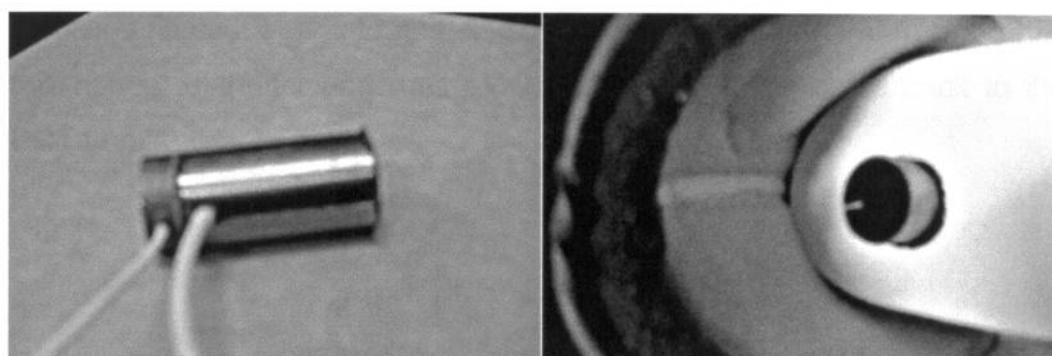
The three-tier piston. The left picture shows the strain gauge attached to the top tier, housing the laser Doppler fluxmeter probe. The bottom tier of the piston is not shown. The picture on the right shows the piston protruding through the shoe during the application of pressure.
